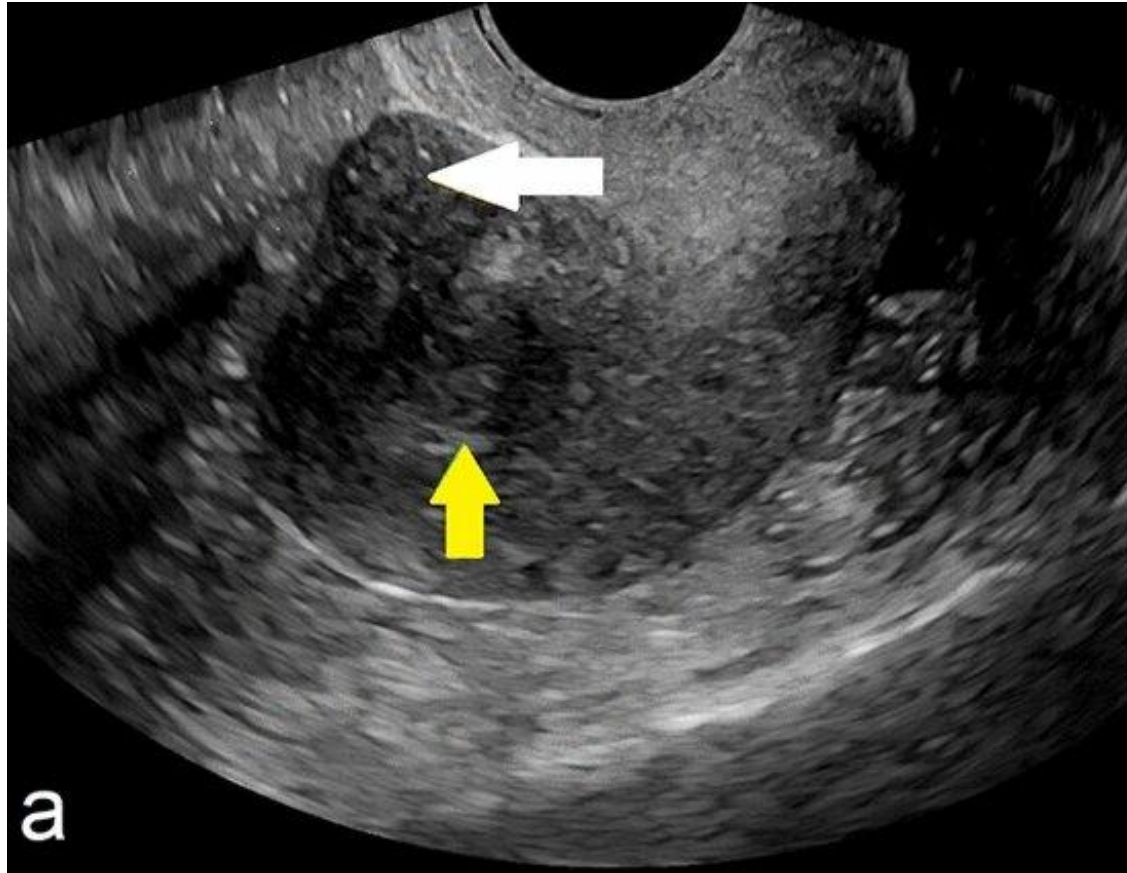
intramural leiomyoma with endometrial abutment. a Longitudinal view on transvaginal ultrasound demonstrating FIGO 3 leiomyoma (white arrows) and its relation with endometrial cavity (yellow arrow). b Transverse view on transvaginal ultrasound demonstrating FIGO 3 leiomyoma contacting the endometrium, but without any submucosal extension (arrows). c 3D ultrasound demonstrating the relation of the leiomyoma to the endometrial cavity (arrows).
